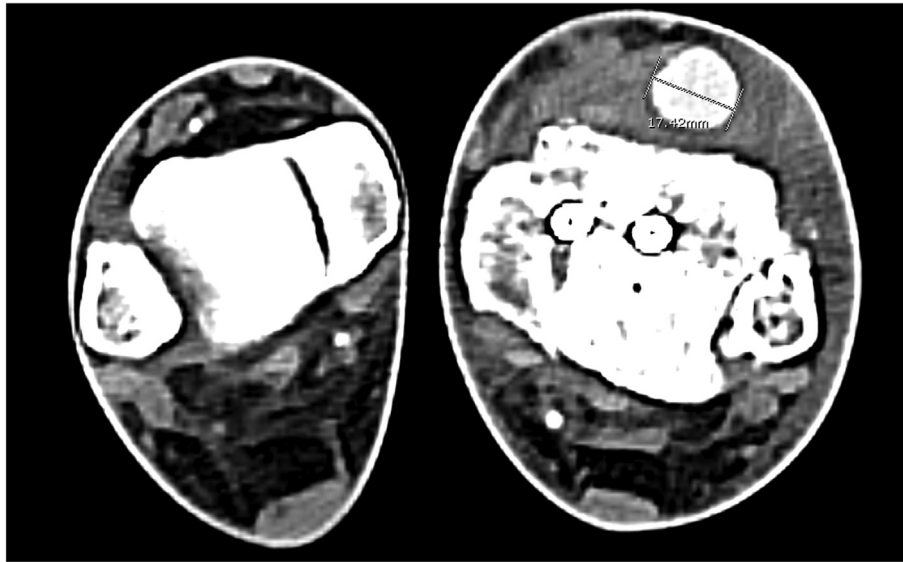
CT angiography axial segments demonstrating the vascular lesion.
